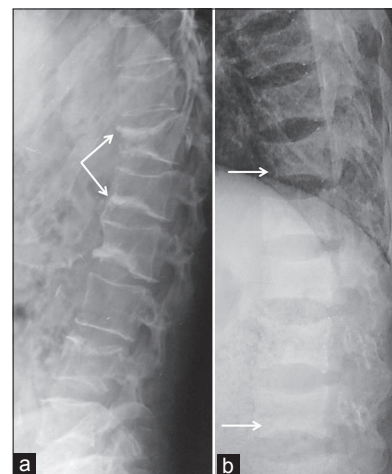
Non osteoporotic vertebral fractures. (a) Lateral radiograph of spine in a patient with Cushing's syndrome shows multiple fractures with sclerosis of end-plates (arrow). (b) Lateral radiograph of spine in a patient with chronic kidney disease and secondary hyperparathyroidism shows biconcave appearance in multiple vertebrae and increased density at end-plates and relatively radiolucent central part suggestive of rugger-jersey spine (arrows)
